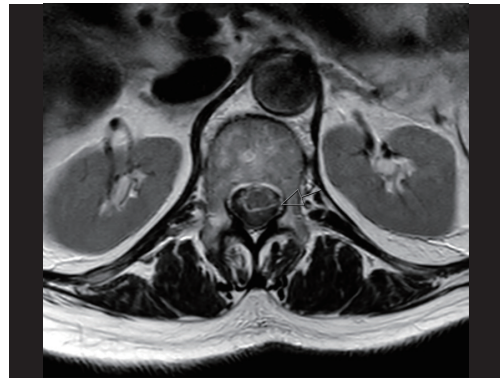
MRI (T2 sequence, axial), the arrow shows the spinal subarachnoid hemorrhage compressing the spinal cord at thoracic vertebrae 12 level. MRI, magnetic resonance imaging.
